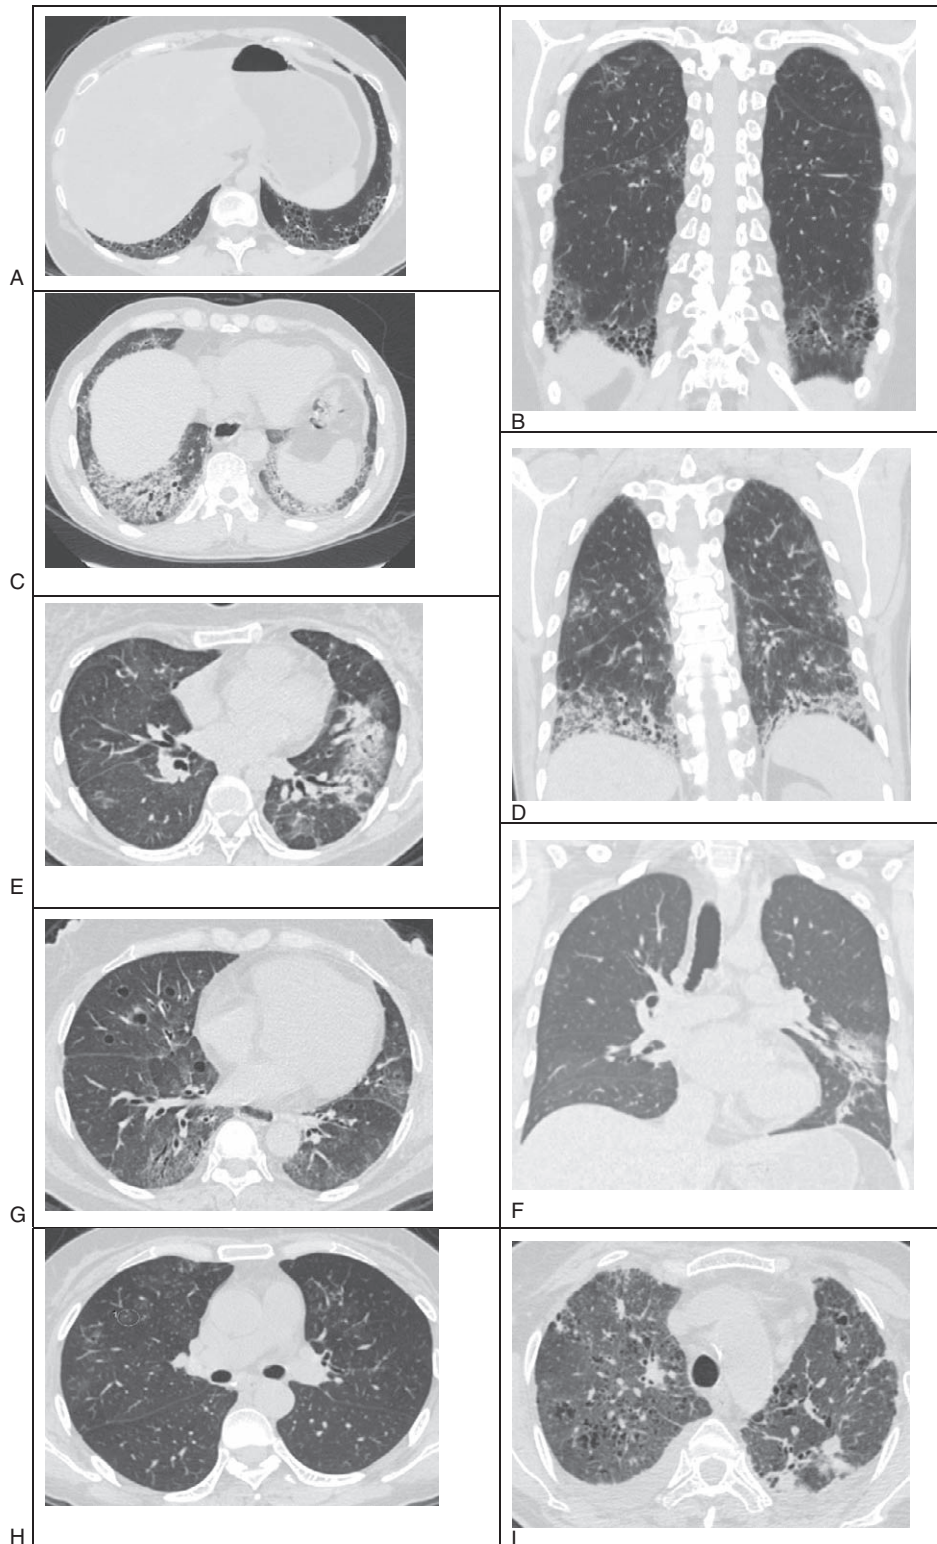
Sjögren syndrome-associated interstitial lung disease (SS-ILD) high-resolution computed tomography (HRCT) patterns. Usual interstitial pneumonia (UIP): (A) axial and (B) coronal CT reconstructions of the chest show fine reticular opacities with honeycombing in the lower lobes, predominantly peripheral and basal patterns of distribution. Nonspecific interstitial pneumonia (NSIP): Axial CT scan of the chest (C) and coronal reformatting (D). Ground-glass opacities with traction bronchiectasis and lower lobe volume loss. Discrete subpleural preservation. Predominantly basal and symmetric patterns of distribution. Cryptogenic organizing pneumonia (COP): axial CT image (E) and coronal formatting (F). Consolidation and ground-glass opacities in left lung. Predominantly subpleural and peribronchial patterns of distribution. Lymphocytic interstitial pneumonia (LIP): CT axial image (G) shows some ground-glass opacities and thin-walled cysts of varying sizes with a diffuse, bilateral distribution. Respiratory bronchiolitis interstitial lung disease (RB-ILD): CT axial image (H) shows mildly extensive ground-glass opacities and centrilobular nodules (in the circle). Desquamative interstitial pneumonia (DIP): CT axial image (I) shows linear reticular opacities with sparse bilateral ground-glass opacity, predominantly distributed peripherally.
